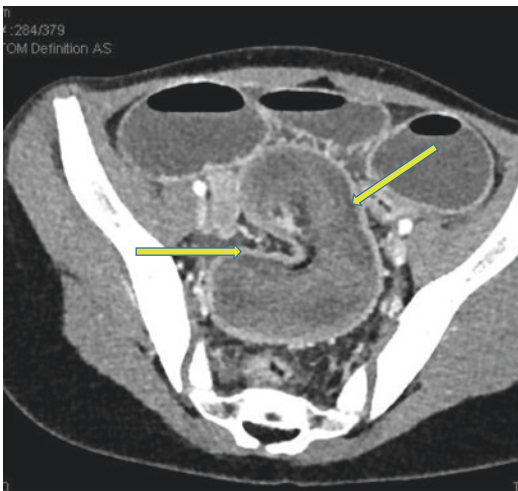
Twelve-year-old child. CE-CT: small bowel obstruction related to a MD volvulus. The MD is distended (yellow arrows), its wall is thickened but remains vascularized
